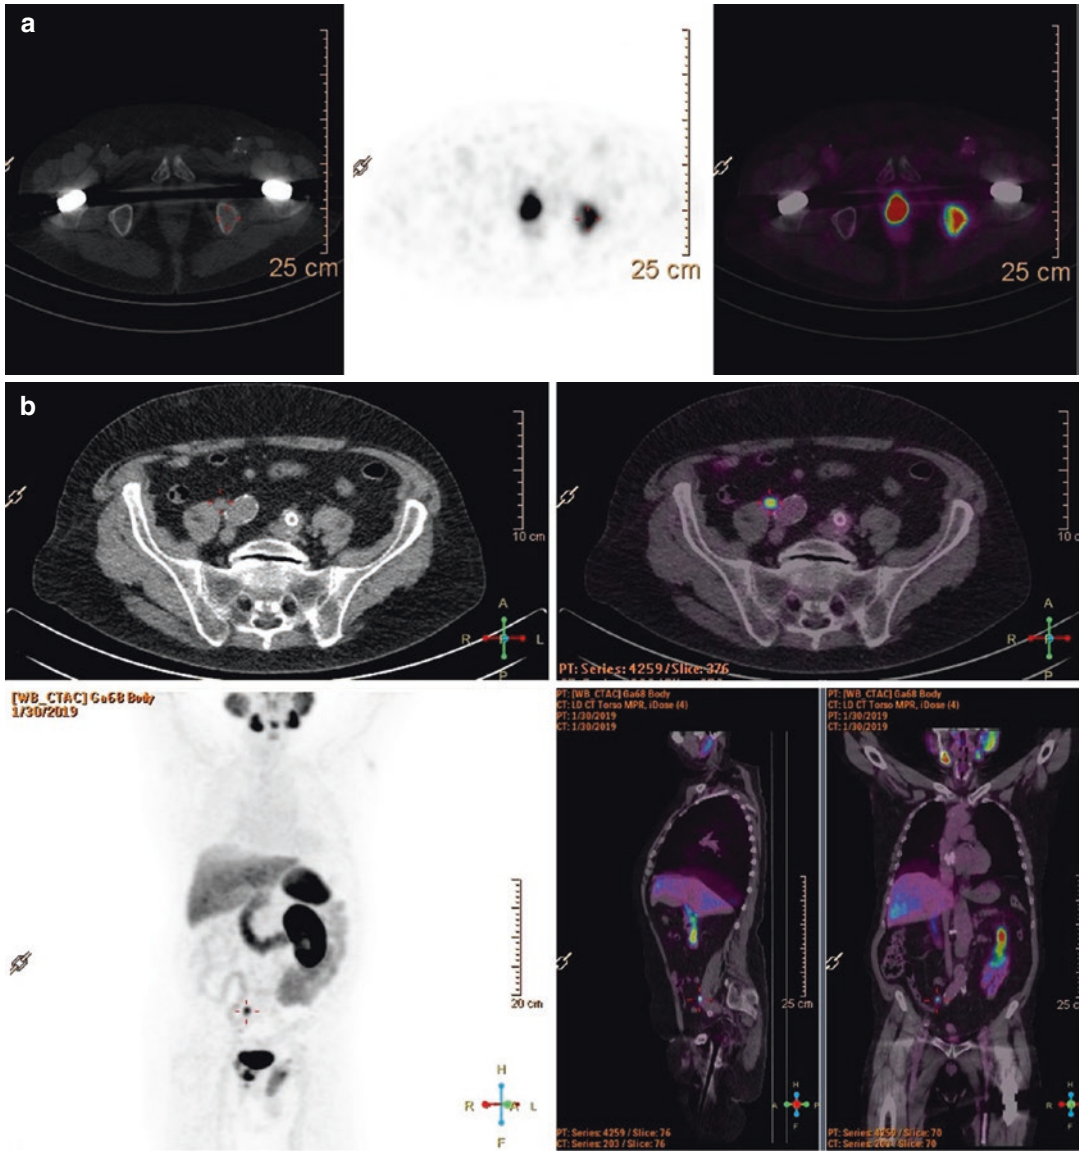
Single bone metastasis in the left os pubis and at least one pelvic lymph node with marked ⁶⁸Ga-PSMA uptake – new findings in respect to a PET/CT three years before. A local relapse in the prostate bed was also present
